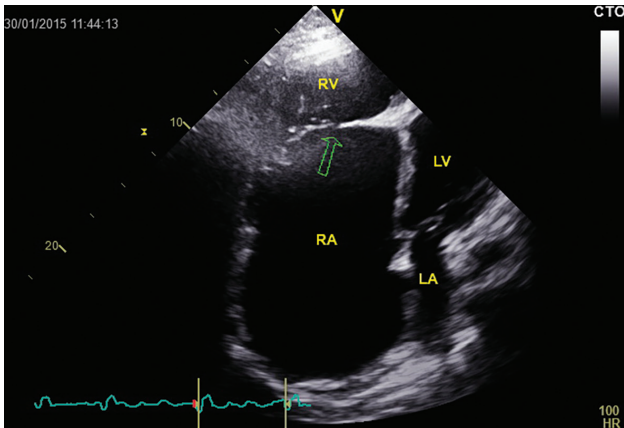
Apical four chamber view – dilated right ventricle with apical displacement of the functional tricuspid annulus (arrow), small functional right ventricle and large dilated “atrialized” portion of the right ventricle.
